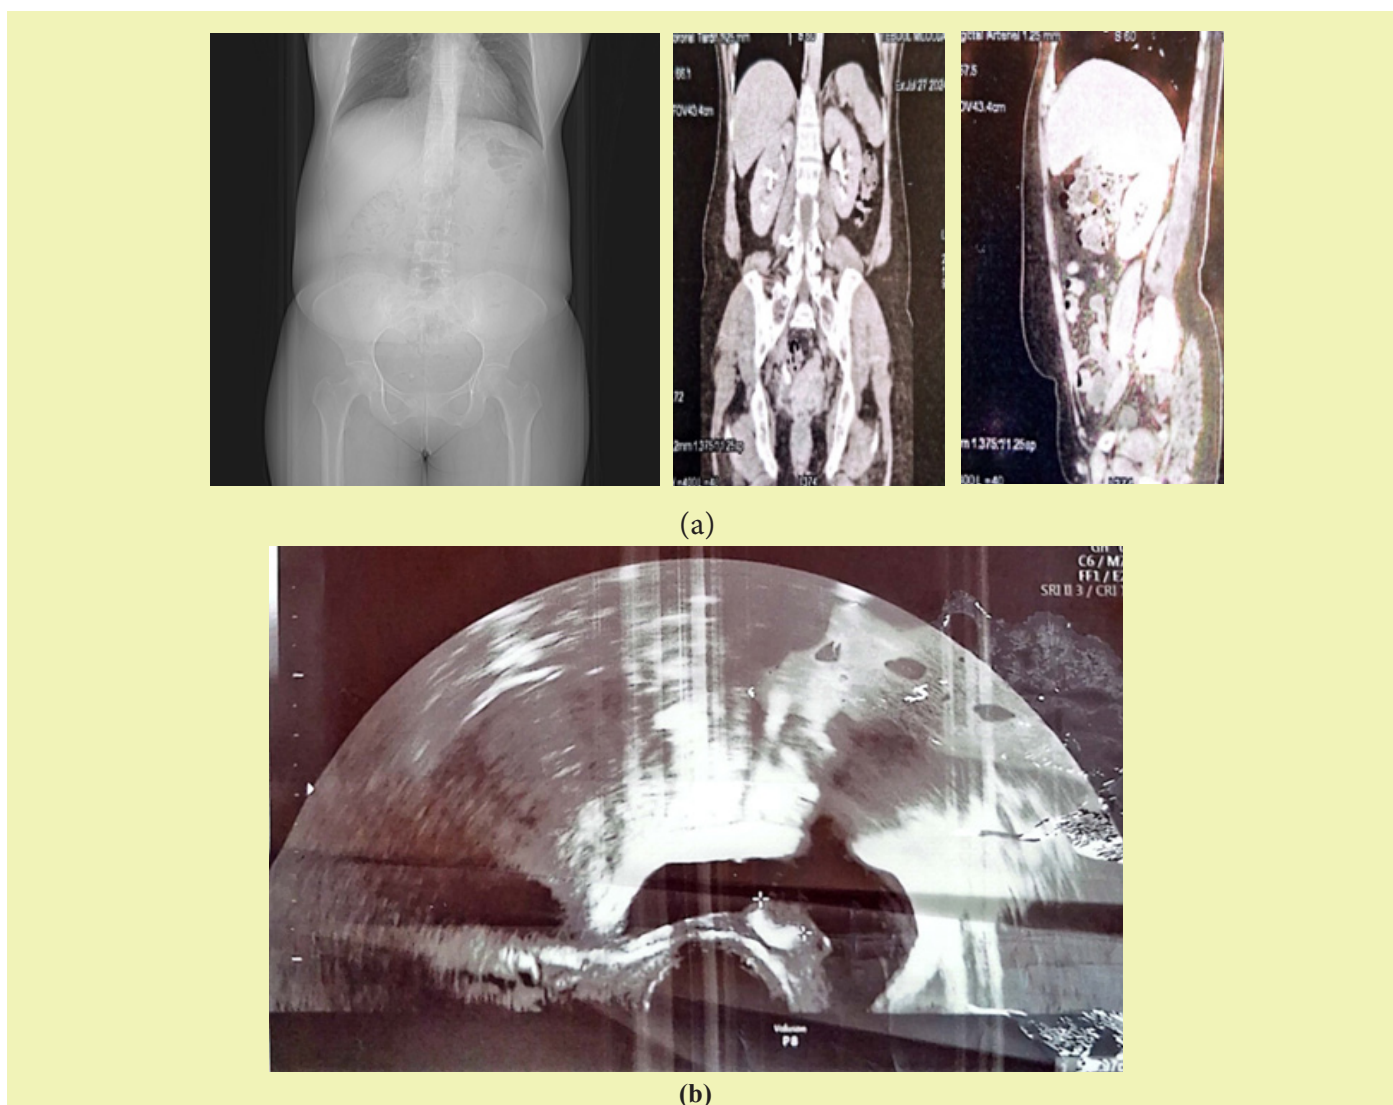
(a) Uro-CT with a urinary stone at the right ureterovesical junction, (b) gynecological ultrasound shows a 1 cm bladder stone
